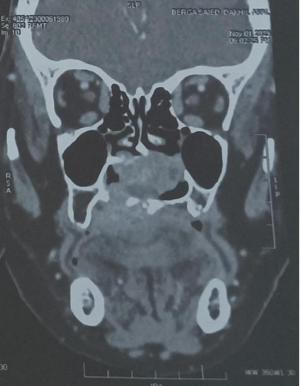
Computed tomography scan showed presence of an infiltrative soft tissue mass centred upon the lower part of nasal cavity. Sagittal and coronal views.
